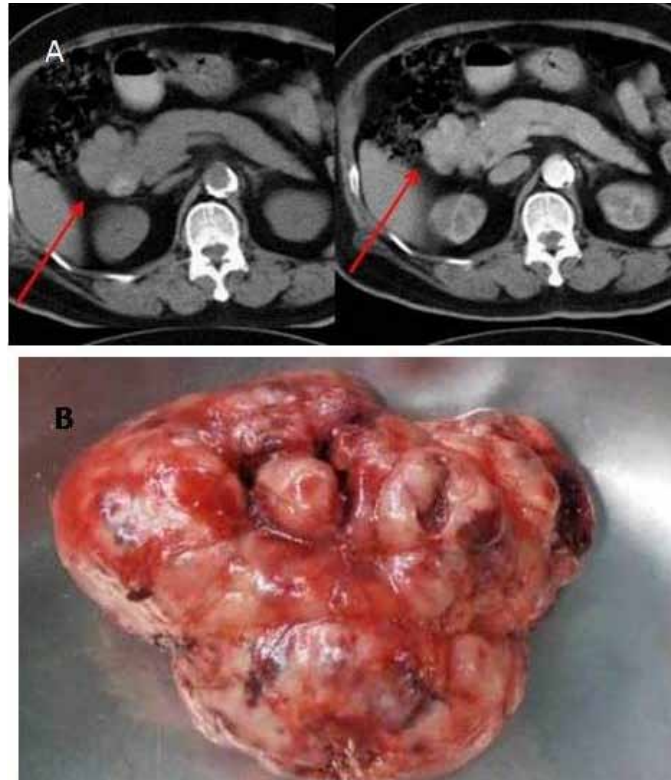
(A) CT showing a well-lobulated mesenteric mass abutting the pancreatic head and a portion of the duodenum. (B) A lobulated, vascular mass with bleeding.
